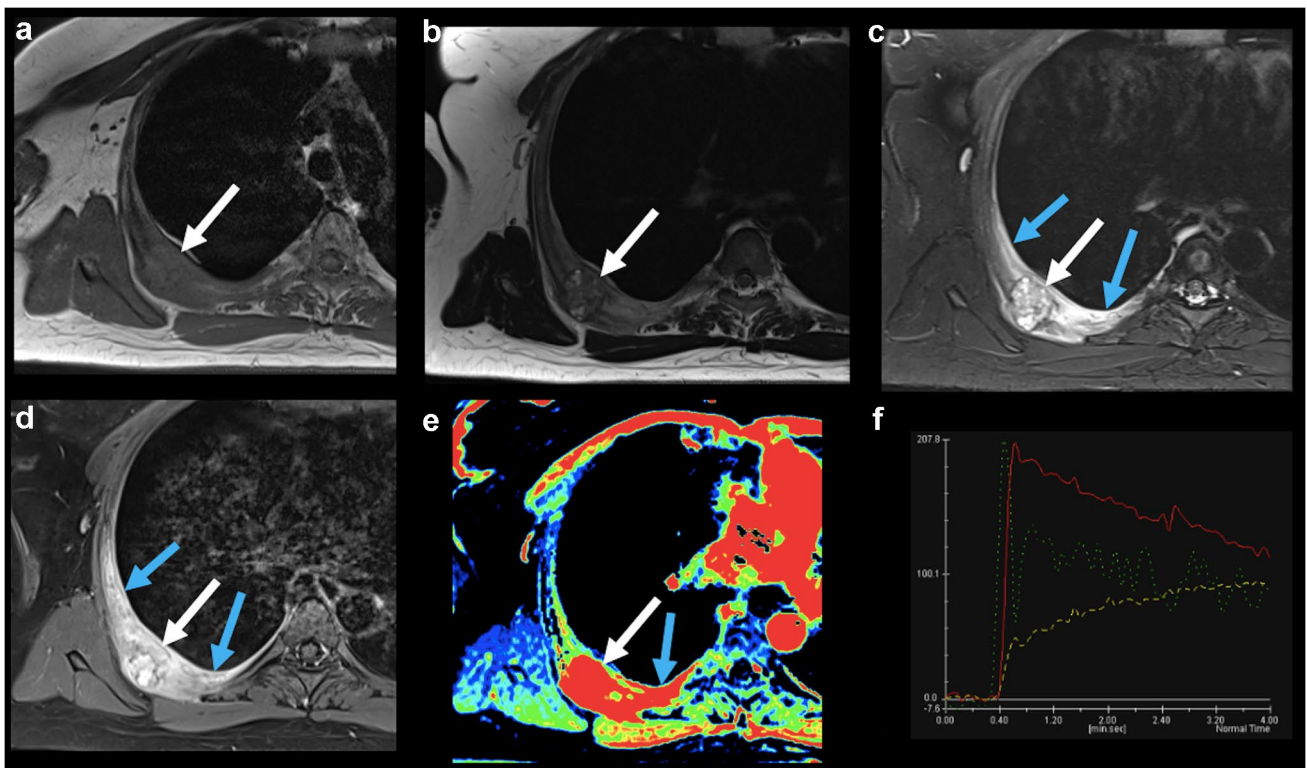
Right fourth rib osteoblastoma. Chest MRI demonstrated an expansile intramedullary lesion in the posterior portion of the right fourth rib, with an isointense signal on T1- (arrow in a), predominantly hypointense signal on T2-weighted imaging (arrow in b), hyperintense signal on STIR (white arrow in c), relative to skeletal muscles, associated with avid gadolinium enhancement on T1-weighted imaging with fat saturation (white arrow in d). Note that there was extensive edema in the adjacent bone marrow and soft tissues, as well as reactive pleural effusion (blue arrows in c), which also presented avid gadolinium enhancement (blue arrows in d). Color-coded semi-quantitative dynamic contrast-enhanced (DCE)
